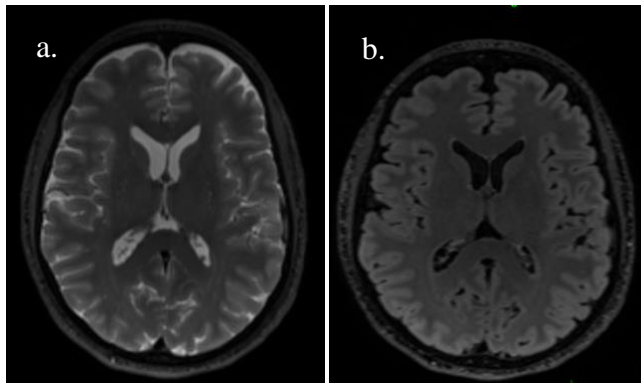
a) T2-W and b) FLAIR MRI images
